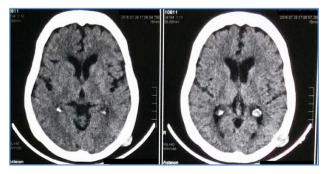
CT Brain Showing Osteolytic Bone Lesion
